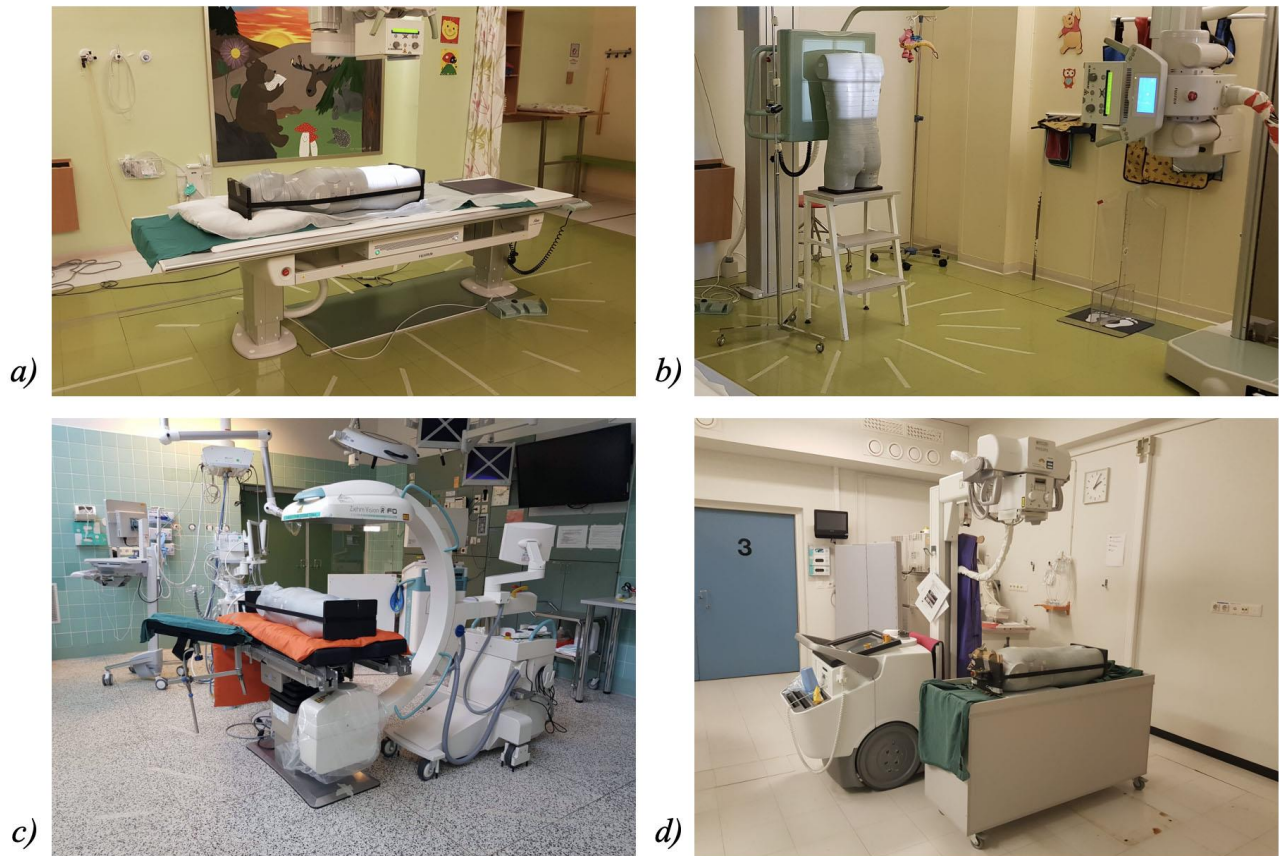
Measuring setups used for: a) supine radiography in the children's X-ray imaging room, b) standing radiography in the children's X-ray imaging room, c) mobile fluoroscopy in the operating room and d) mobile supine radiography in the general X-ray examination room.
